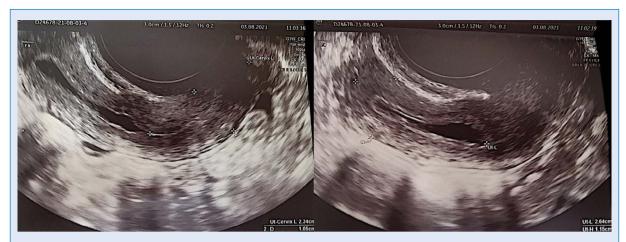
Current uterus ultrasound picture
